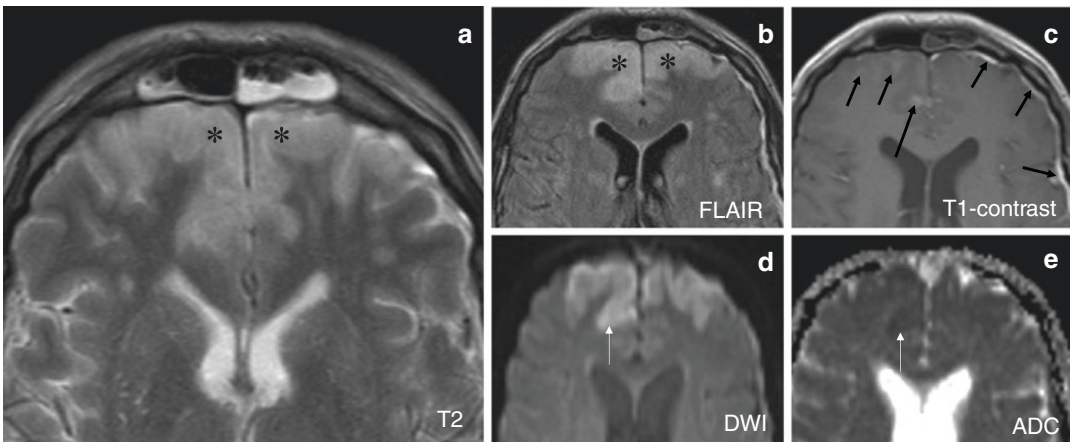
Cerebritis secondary to frontal sinusitis. Frontal cortical and subcortical swelling and high signal on FLAIR (d) and T2 weighted MRI (e, asterisks). This shows mildly restricted diffusion based on the DWI (a, black arrow) and ADC map (b). Post contrast T1 weighted MRI shows patchy dural and cortical enhancement
